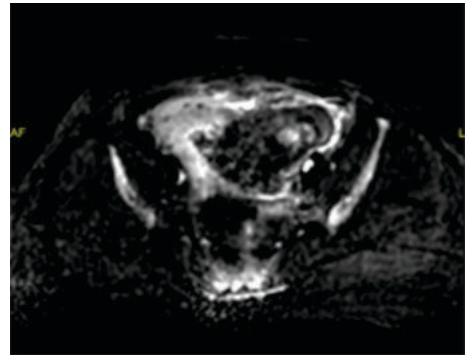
MRI DWI imaging shows no diffusion restriction suggesting the absence of infective collection.
